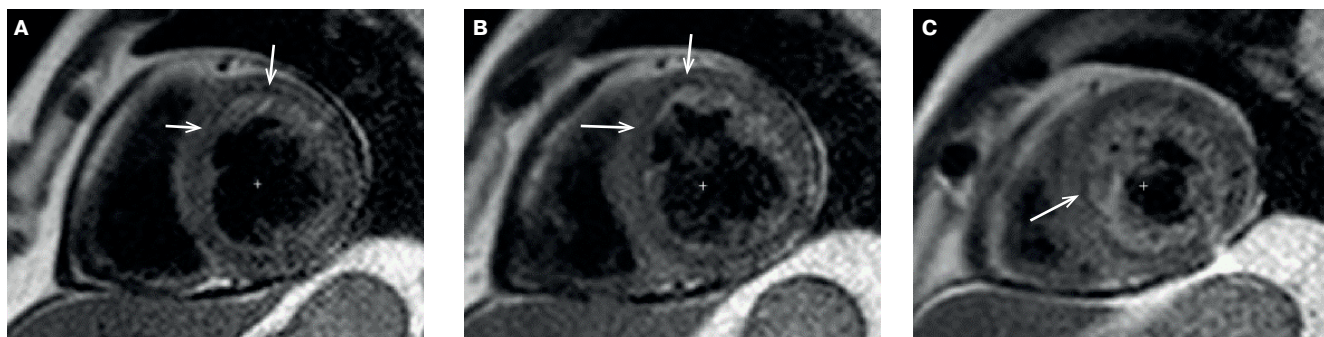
Intramyocardial haemorrhage by cardiac MRI. The short axis of the basal, middle, and apical (A, B, C) LV levels. Note: arrows show hypointense areas in the projection of the LV anterior wall (A, B) and inferior lateral wall (B, C) in the T2-WI mode.
